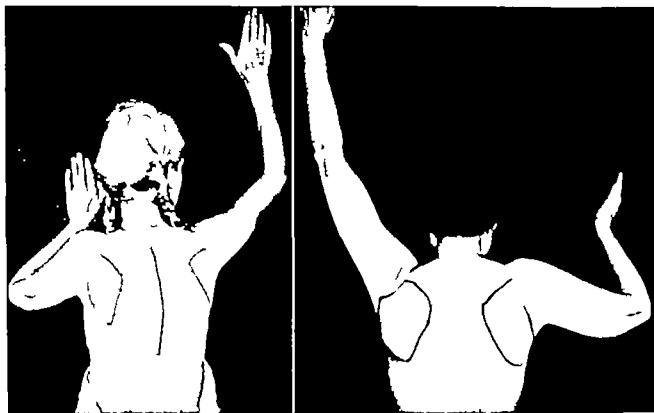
(*Left*) Characteristic features of a patient with a left frozen shoulder. The patient's general health is below par—she has been a victim of bronchiectasis for many years. Note the relation of the axis of the shaft of the humerus to that of the spine of the scapula forming approximately a right angle. This relationship is maintained during all movements of the arm and is more clearly discernible in roentgenograms taken during different stages of elevation of the arm.
